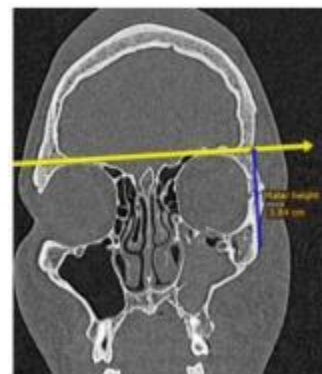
Preoperative radiographic malar height on the fracture side.
